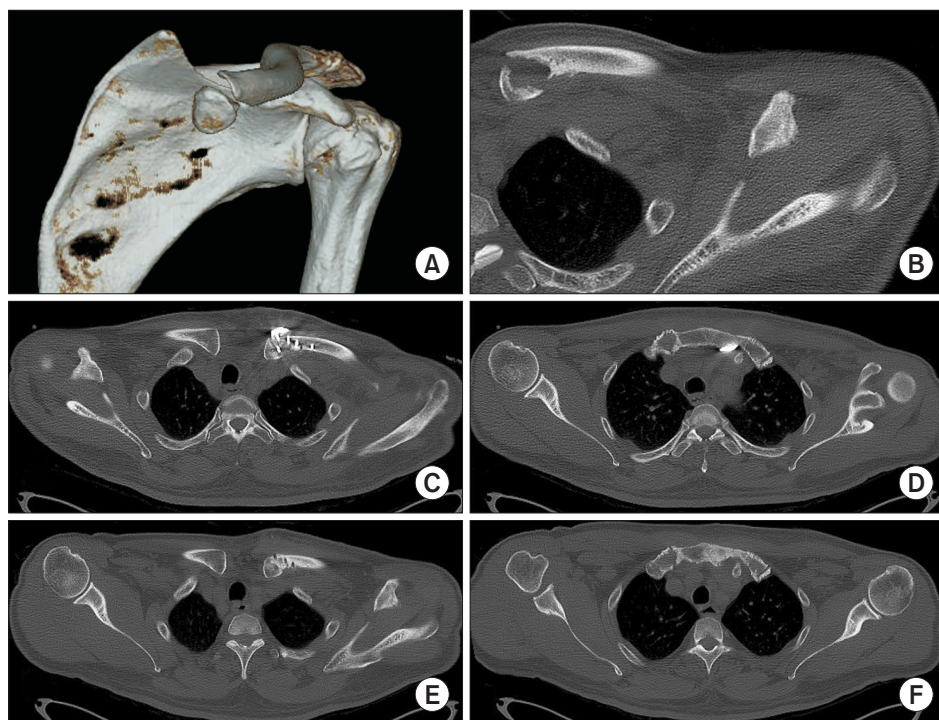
(A, B) Three-dimensional computed tomography (3D-CT) images of a 56-year-old man who presented with nonunion of a medial-end clavicle fracture. (C, D) A clavicle hook plating was performed with an autologous bone graft. (D, F) At 6-month postoperative CT follow-up, the union of fracture site was shown without osteolysis.
